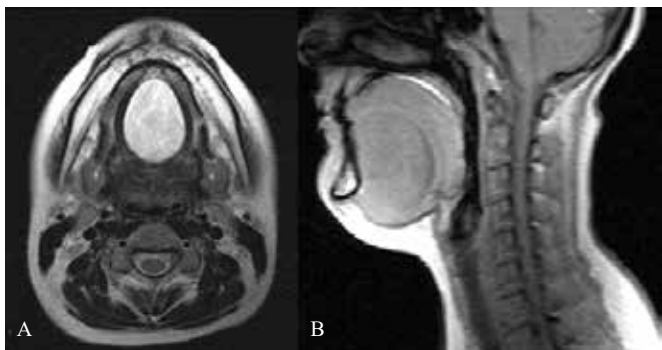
T1-weighted MR images show heterogeneous hyperintense cystic mass at sublingual region. (A) Axial, (B) sagittal.
